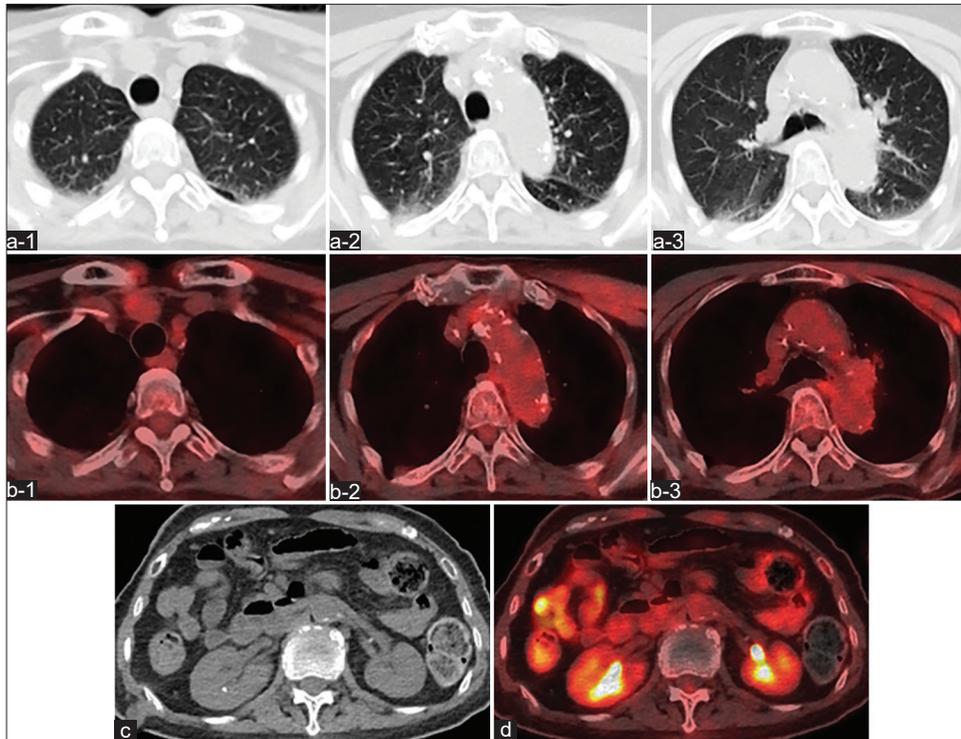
Whole body computed tomography (a-1 - a-3 and c) and ^{18}F -fluorodeoxyglucose (FDG)-positron emission tomography (b-1 - b-3 and d) obtained after three cycles of chemotherapy show complete disappearance of the abnormal signs and FDG accumulation identified on admission, indicating achievement of complete remission.
